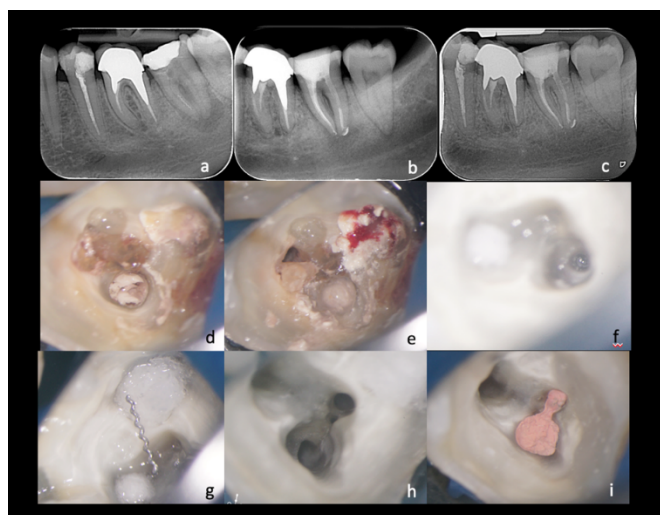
a) Pre-operative x-ray; b) Post-operative x-ray); c) 2-year follow-up; d) and e) Pulp chamber before retreatment; f) Fractured instrument inside the mesio-buccal canal (visible under magnification); g) Removal of the fractured instrument; h) Cavity before obturation (the compromise of the orifice is not minimal due to an invasive initial management); i) Obturation of the mesial canals.
